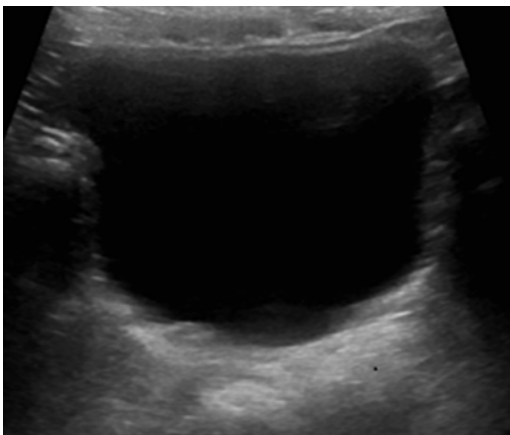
Ultrasound of normal bladder. Urine within bladder appears black or anechoic
